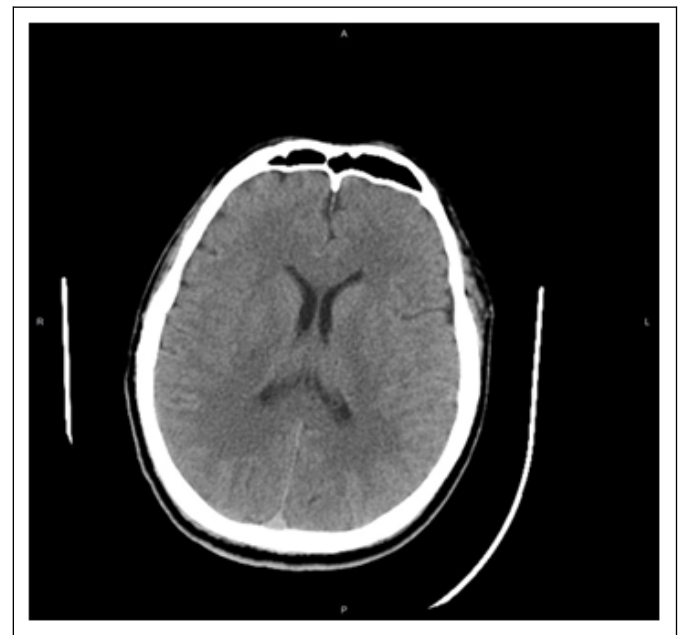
Non-contrast routine brain CT scan examination during admission.
